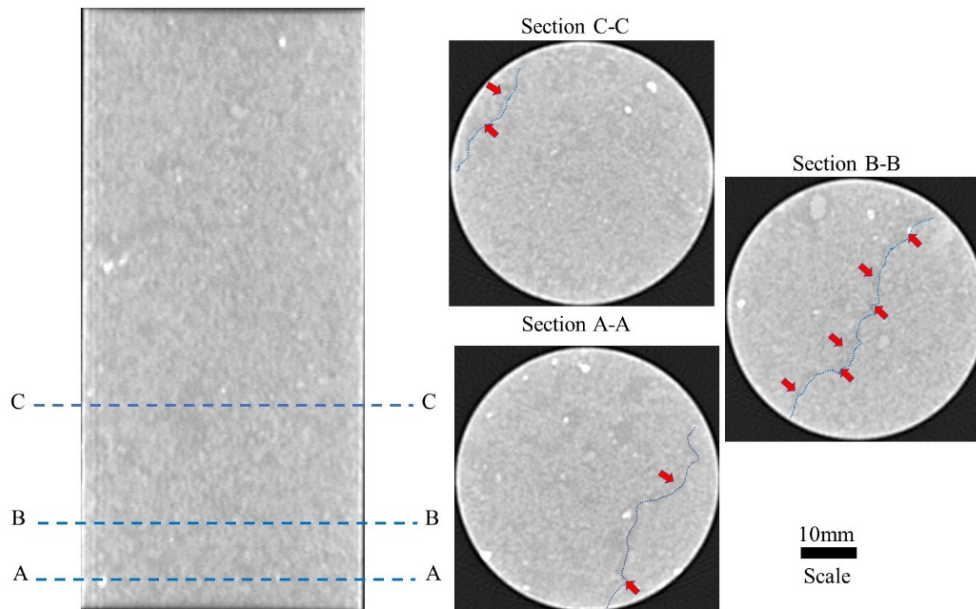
CT scan slices for a dolerite sample showing a tiny pre-existing microcrack inside the sample.
